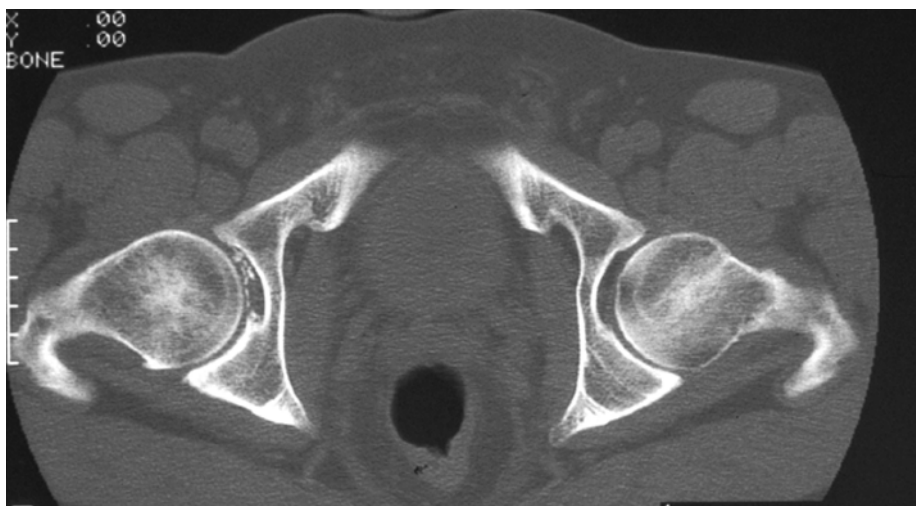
Loose bodies demonstrated on CT scan.
